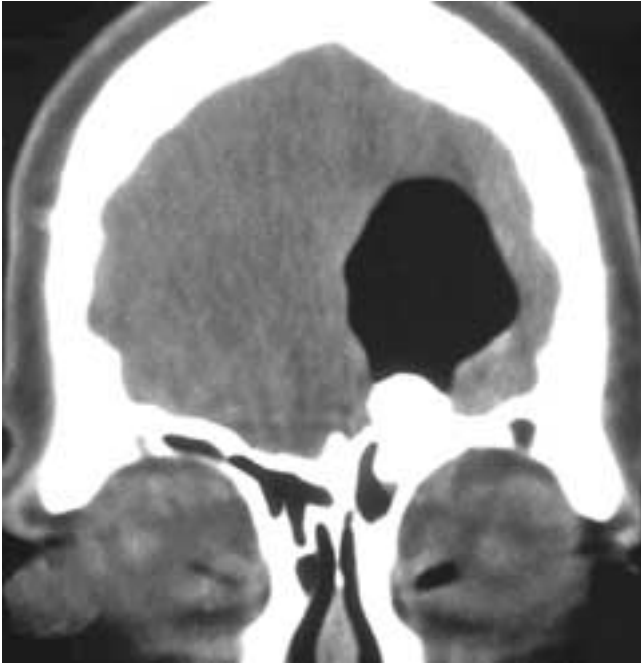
Coronal CT scan shows an osteoma in the roof of the left frontal sinus with a large collection of intracranial air.
